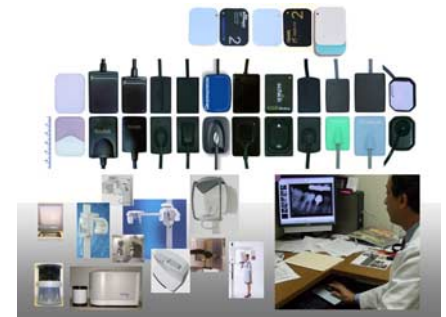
A sample of digital intraoral detectors compared with size #2 analog film (top), a sample of digital panoramic systems (lower left), and an endodontist using digital radiographs for case assessment (lower right).
